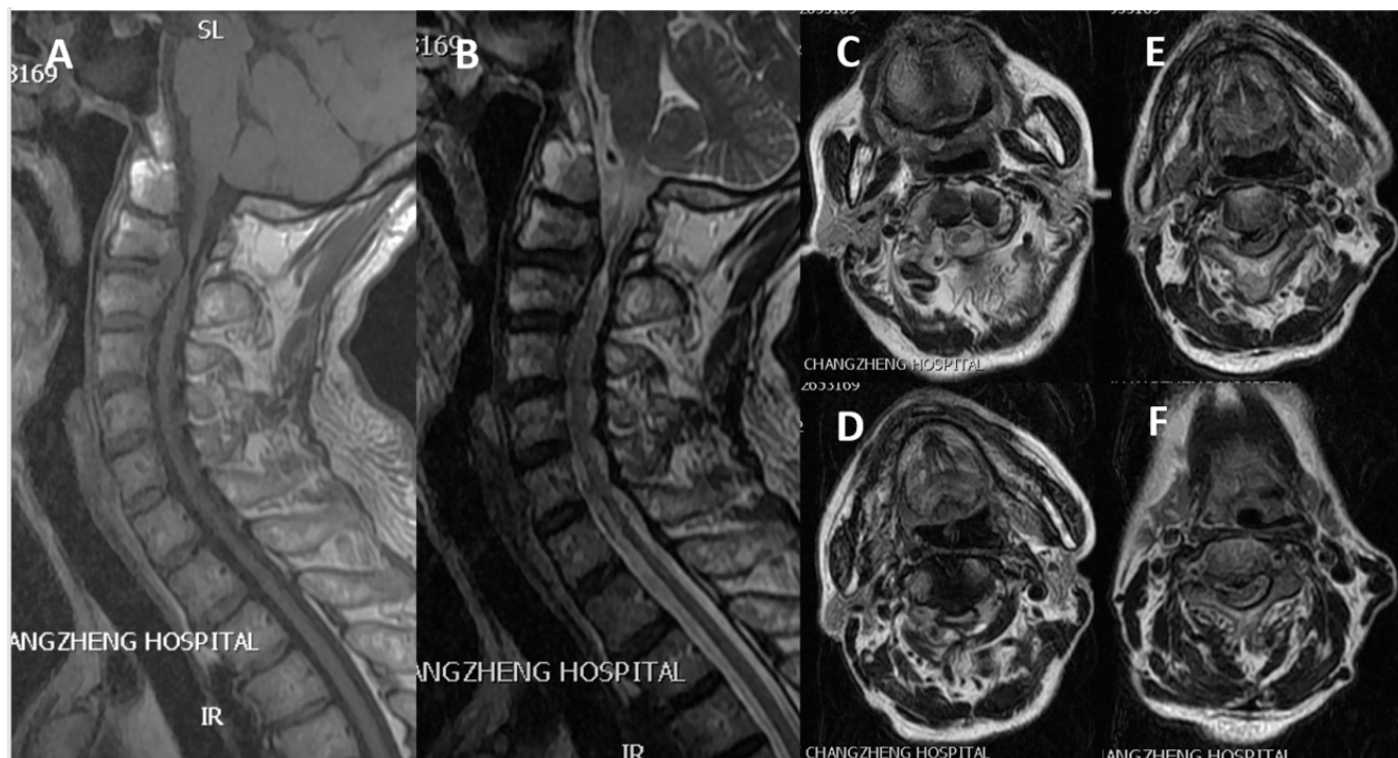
MRI of the cervical spine. (A) T1-weighted sagittal MRI image showing posterior herniation of the C2/3 intervertebral disc, causing spinal cord compression; (B) T2-weighted image showing spinal cord compression at C2/3 intervertebral space with a long T2 signal; (C) Axial plane at the C1/2 level showing a small spinal cord diameter with no compression; the left vertebral artery runs laterally from the C2 lateral mass to the posterior aspect and returns to the medial side; (D) Axial plane at C2/3 level showing cervical disc herniation and severe spinal cord compression; (E) Axial plane at C3 level showing a sharp, point-like ossification at the posterior vertebral margin protruding into the spinal canal, causing severe spinal cord compression; (F) Transverse image at C4 level showing posterior vertebral ossification but no spinal cord compression.
